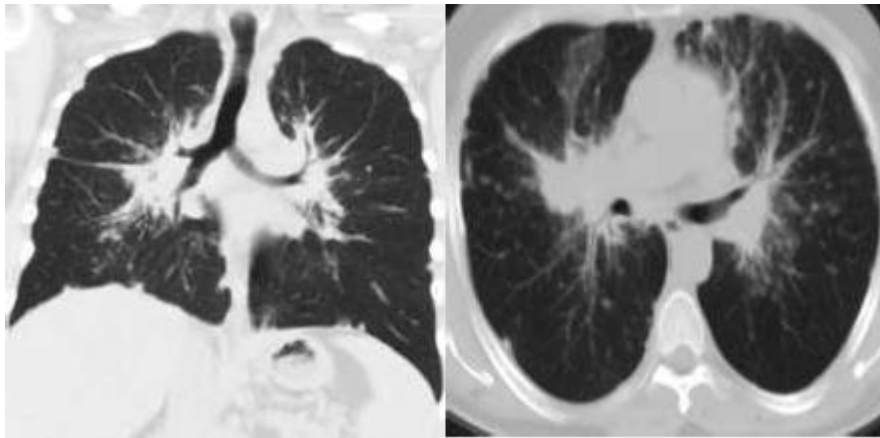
CT picture of bilateral hilar densities, representing hilar lymphadenopathy, associated with Bilateral pulmonary micro-nodules distributed in a peri-lymphatic distribution, including perifissural nodules and peri-broncho-vascular nodules, picture suggestive of Sarcoidosis, on top of differential diagnostic list of interstitial lung diseases.
